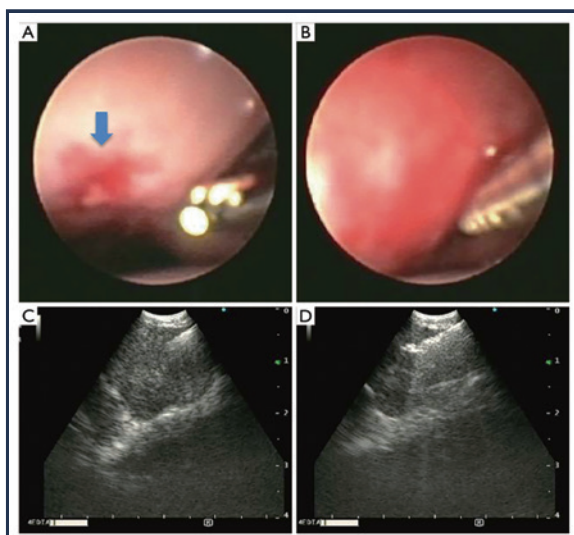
(A) Endobronchial view of mini-forceps, blue arrow points to the puncture site formed by TBNA needle. (B) Mini-forceps penetrate into the airway wall. (C) Endobronchial ultrasound view of the mini-forceps inside the lymph node. (D) The mini-forceps advanced and opened inside the target lymph node and ready to take biopsy (Excerpted from Cheng G, Mahajan A, Oh S, et al. Endobronchial ultrasound-guided intranodal forceps biopsy (EBUS-IFB)-technical review. *J Thorac Dis*. 2019 Sep;11(9):4049-4058. doi: 10.21037/jtd.2019.08.106.)
